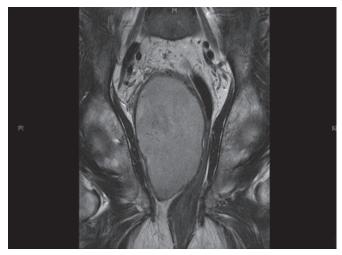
Magnetic resonance imaging of the abdomen and pelvis showing a large right presacral mass, whose appearance could suggest a neurogenic tumor
